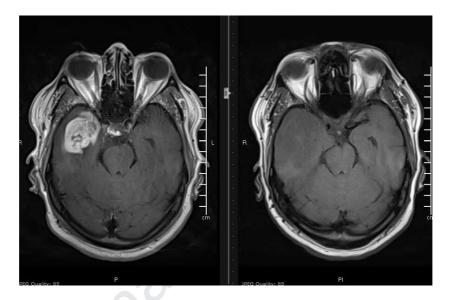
MRI Head T1 on right side, T2 left side
